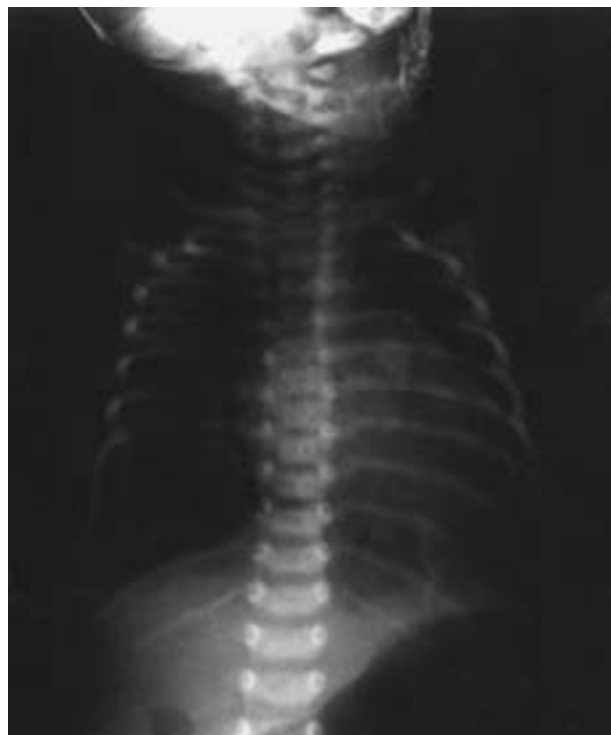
Cardiomegaly was visualized on chest radiography.
